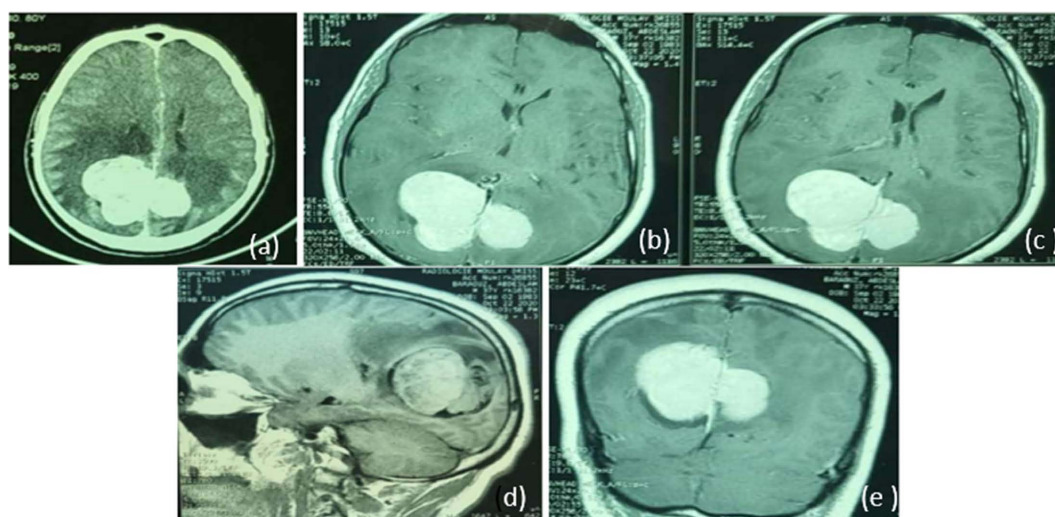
(a) Contrast-enhanced brain CT scan revealed a tumor in the median temporo-occipital region, measuring $90 \times 57 \times 51$ mm, with a hyperdense base, well-defined contours, and poly-lobulated shape. This lesion showed intense enhancement, surrounded by a hypodense area infiltrating adjacent white matter., axial section; (b) (c) MRI, axial T1 with contrast; (d) (e) MRI, sagittal and coronal T1 with contrast, coronal T1 with contrast, extra-parenchymal lesion located at the falx cerebri, with significant enhancement and surrounding edema, causing a slight displacement of midline structures.
